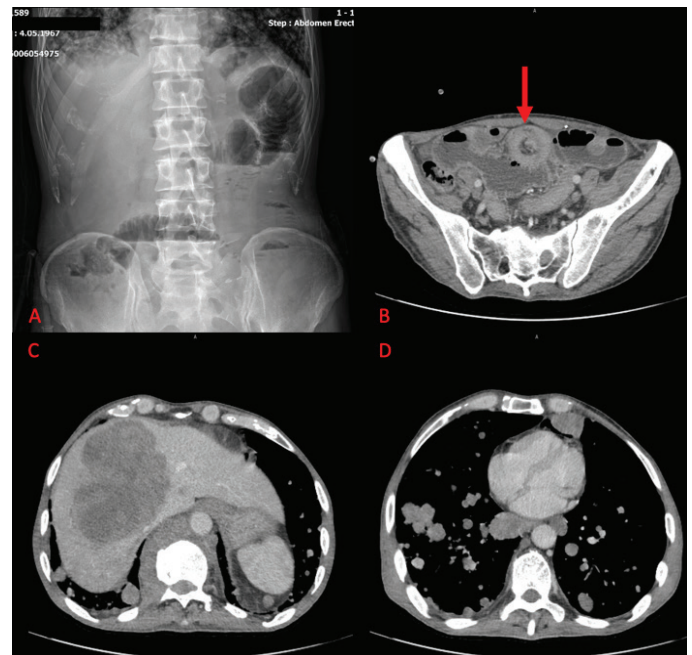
The air-fluid levels are observed at the level of the small intestine (A). The “target” finding on the CT scan is indicated by the arrow (B). The presence of liver metastases is evident (C). Widespread lung metastases are also observed (D)
